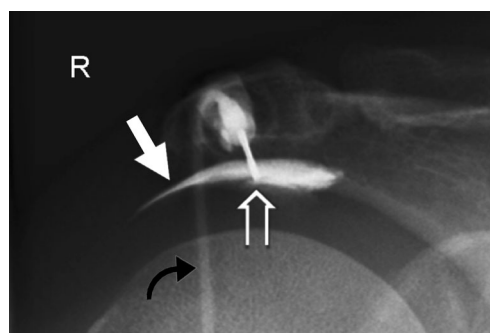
A 53-year-old woman with subacromial shoulder impingement underwent subacromial infiltration. The radiograph demonstrates the correct position of the injection needle tip (open white arrow) and typical subacromial contrast agent distribution (bold white arrow). The curved black arrow indicates the connection tube between the syringe (not shown) and the injection needle
